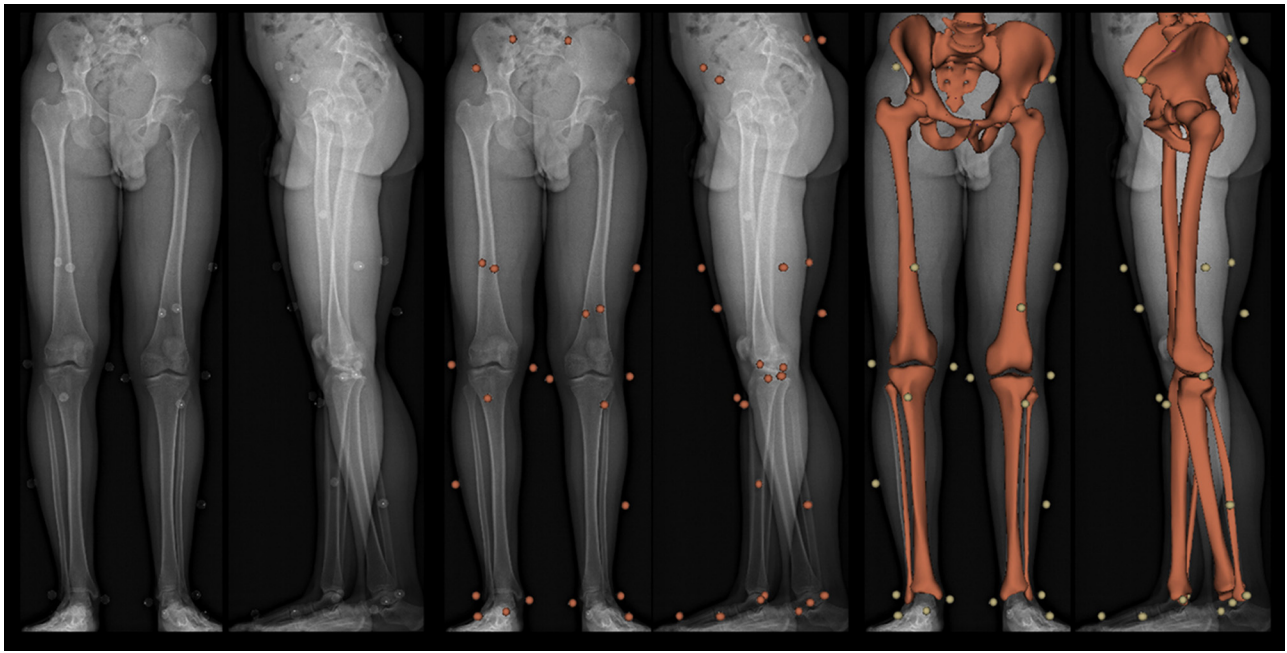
Frontal and lateral EOS radiographs (left) with 3D reconstruction of the external markers (middle) and of the lower limbs and pelvis (right).
